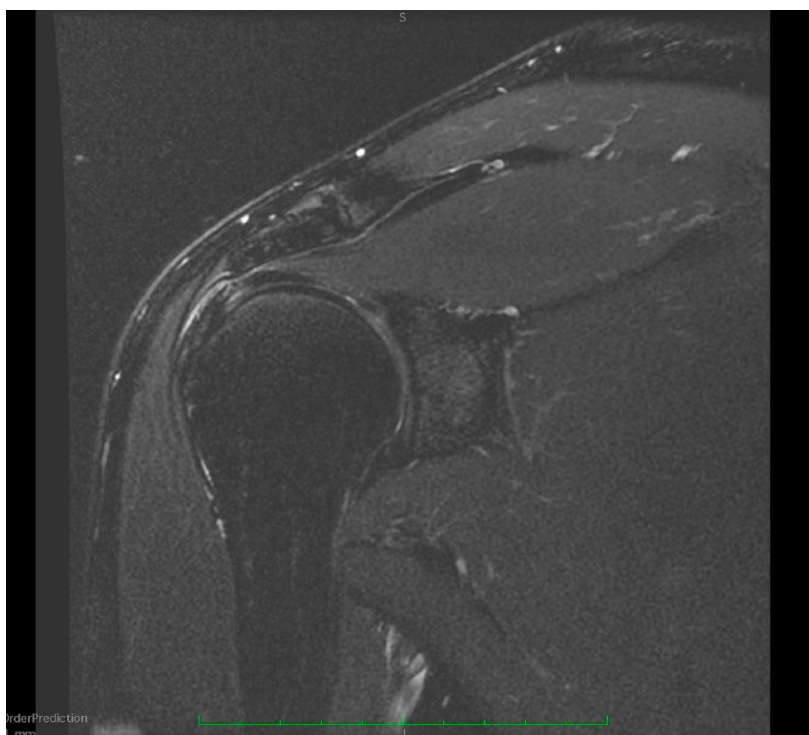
Detection of lesions through magnetic resonance imaging.
